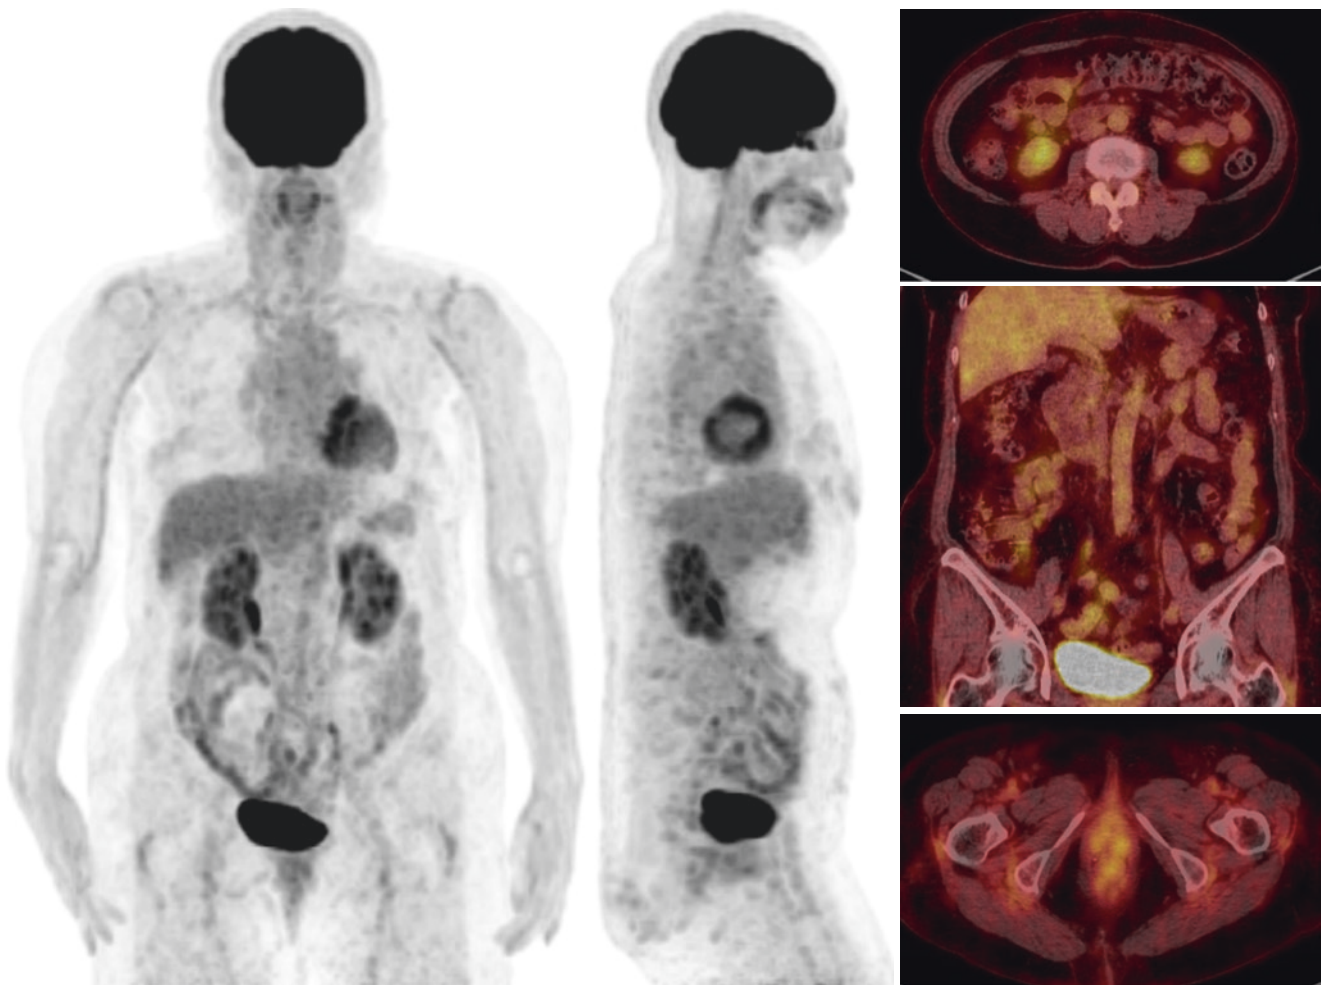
^{18}F -FDG-PET/CT images after therapy
